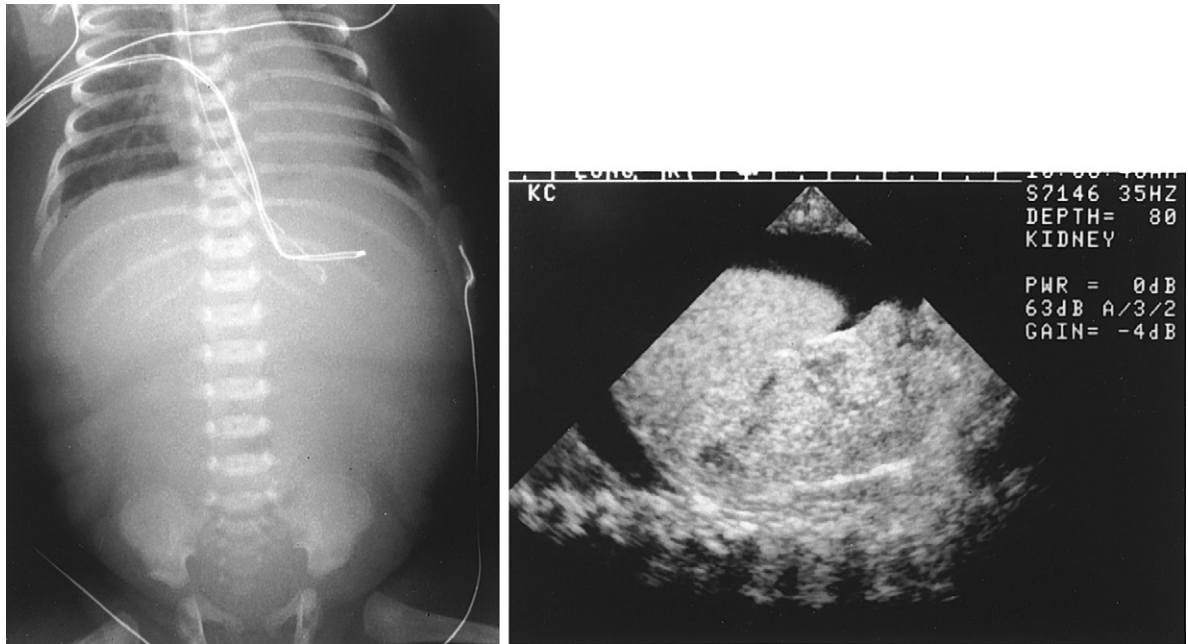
A newborn with hepatocellular ascites. The plain radiograph shows diffuse opacification with minimal bowel gas; the ultrasonogram shows fluid in the hepatorenal fossa.
